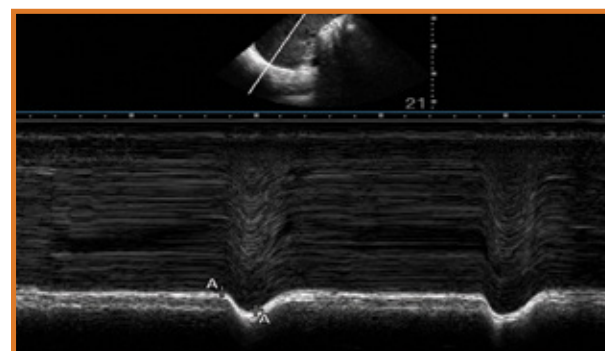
Paradoxical motion in the right hemidiaphragm with rapid sniff maneuver on ultrasound.
